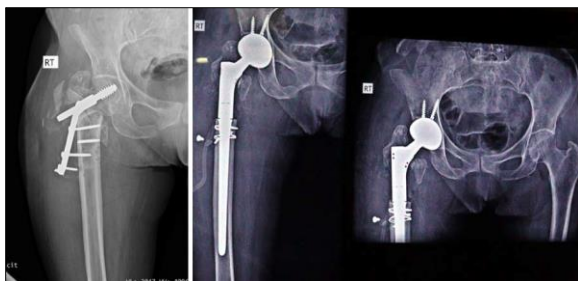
Preop x-ray and postop x-ray of Proximal femoral replacement arthroplasty.
